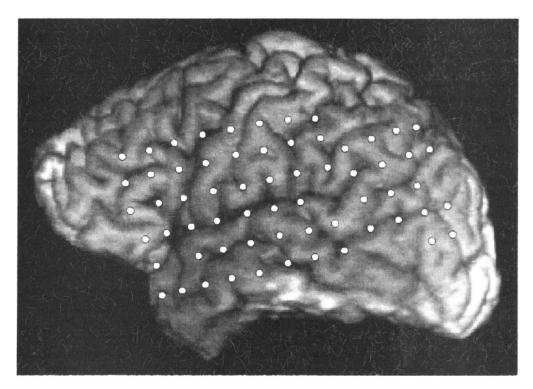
Superimposed 3-dimensional CT-MRI reconstruction of subdural electrode array coverage in Patient 6. (Note: center-to-center, inter-electrode distance is 1 cm; exposed electrode surface is 2 mm.)
